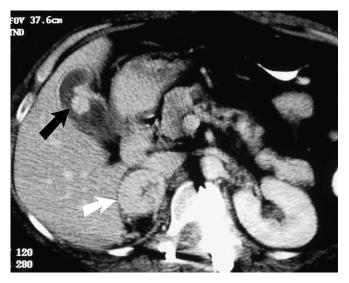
A 65-year-old patient with a history of right nephrectomy for renal cell carcinoma 3 years earlier. The arterial phase of the contrast-enhanced computed tomography demonstrates metastatic disease in the gallbladder (black arrow) and right adrenal gland (white arrow).
